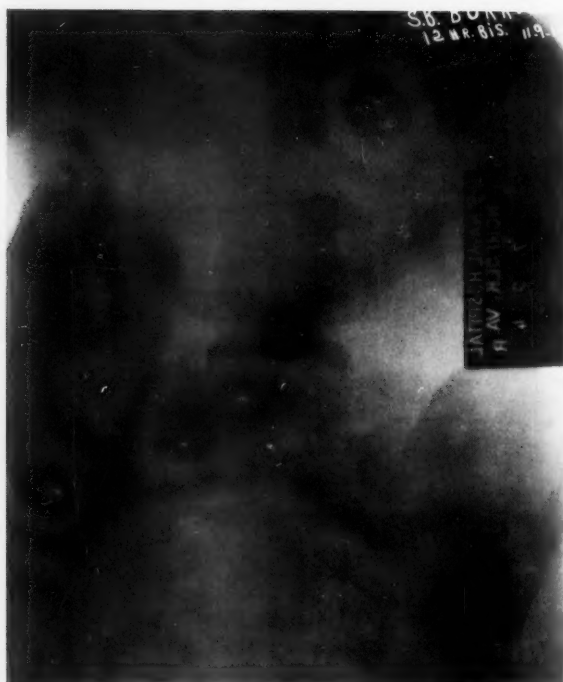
Case XV. Plate 11. Radiograph taken twelve hours after bismuth meal, showing obstruction at hepatic flexure. At operation Lane's kink and Jackson's membrane. Obstruction in terminal ileum and at hepatic flexure.
